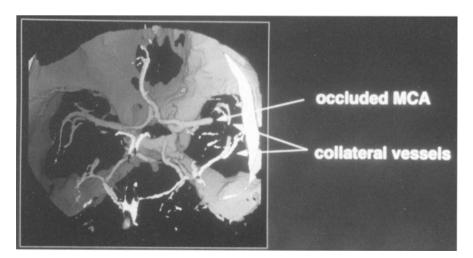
CTA demonstrating occluded left middle cerebral artery. (Figure courtesy of Dr. Werner Hacke and Dr. Klaus Sartor, Heidelberg, Germany)
